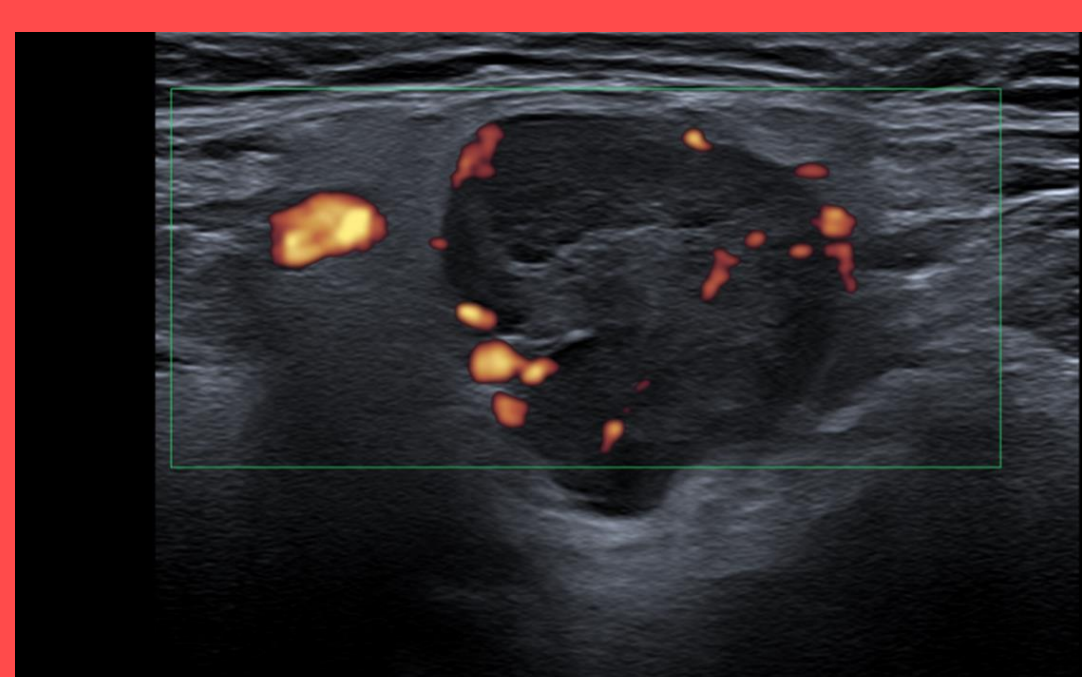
US Right SMG mass showing Power Doppler flow
